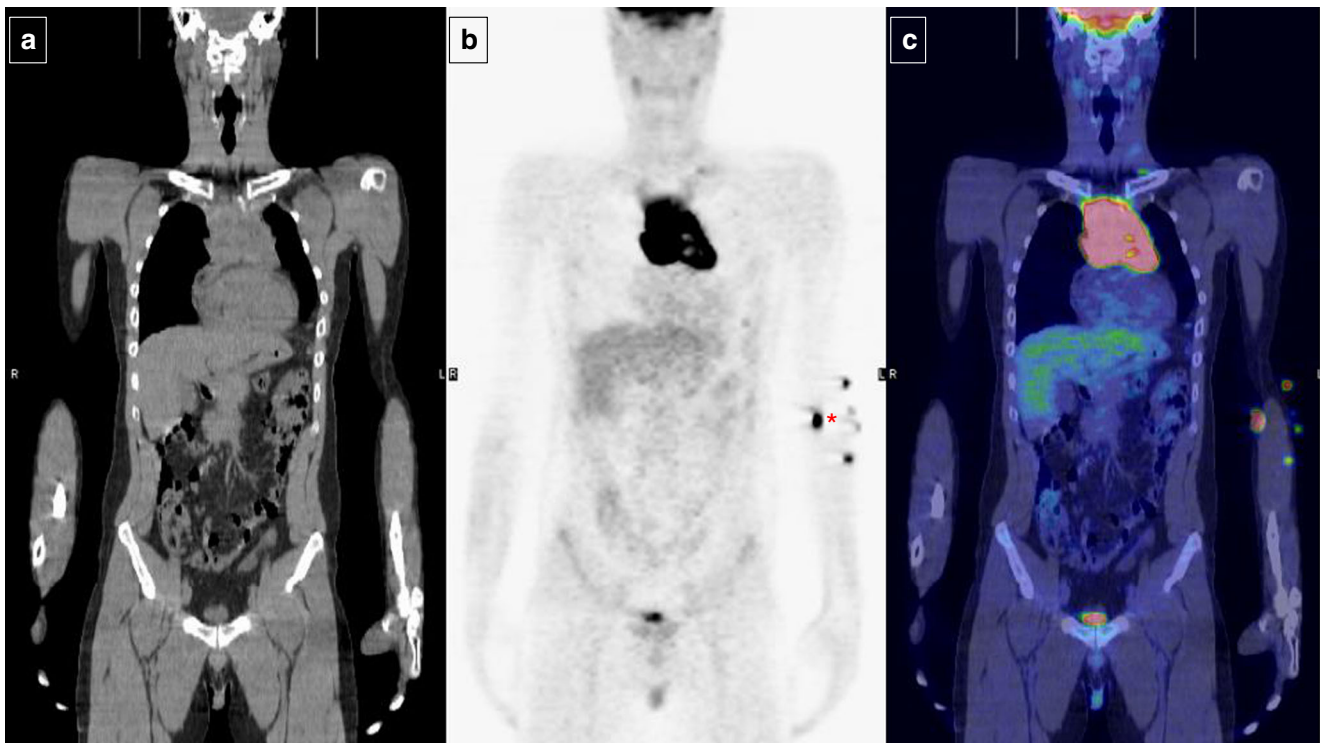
PET/CT imaging in an example patient with a bulky mass in the mediastinum defined on the basis of a mediastinum/thorax ratio of ≥ 0.33 , calculated on an anterior–posterior plain radiograph of the thorax. (a)
